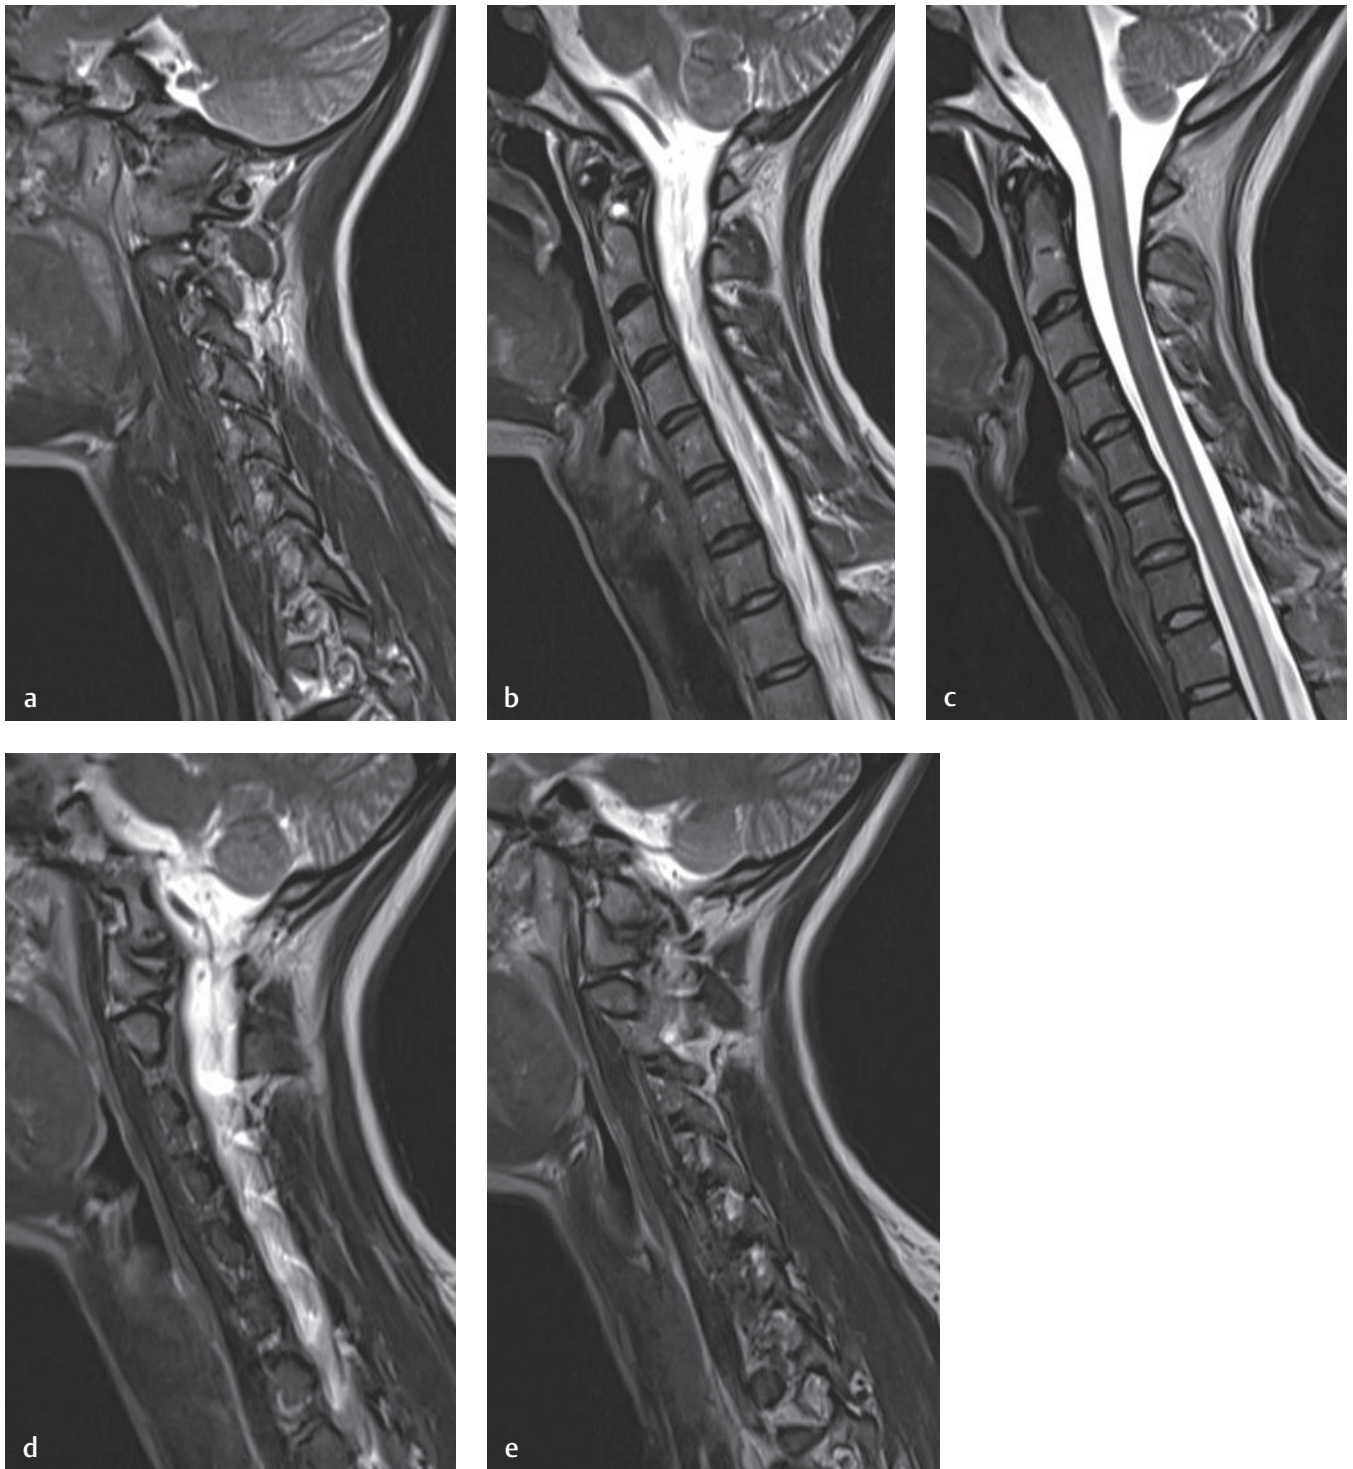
Sequential sagittal imaging of the cervical spine. These T2-weighted images should be viewed in order from (a) left to (e) right. The midline image (c) should be identified.[†]
